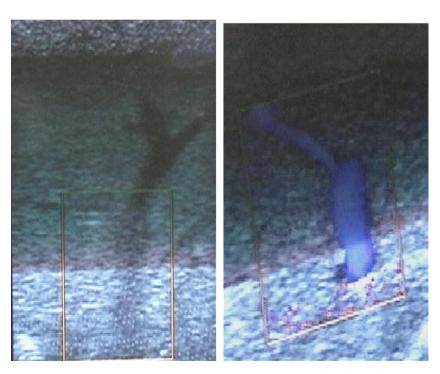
Intraoperative color-Doppler ultrasonography shows normal grade venous flow from inferior right hepatic vein.
